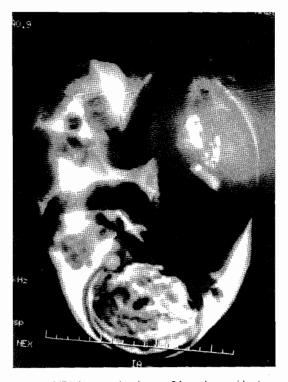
MRI image showing a 34-week gravid uterus containing a single child in normal position and with normal features
